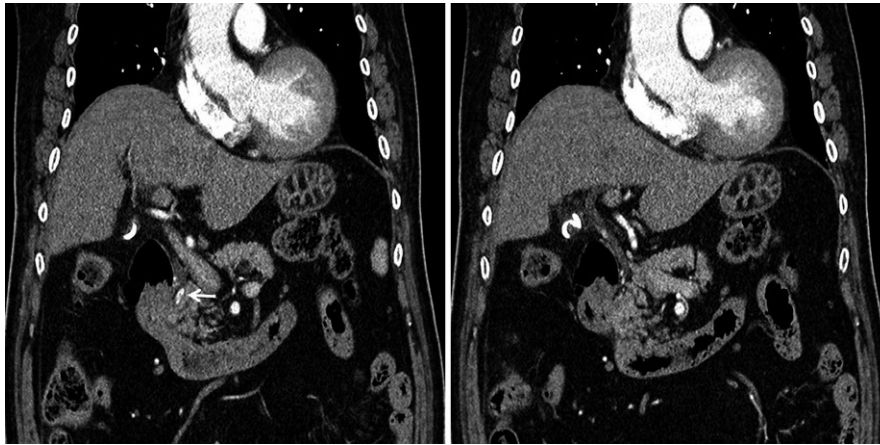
Abdominal computed tomography scan shows distal common bile duct stone (arrow) and periampullary diverticulum without dilatation of the intrahepatic duct and common bile duct
